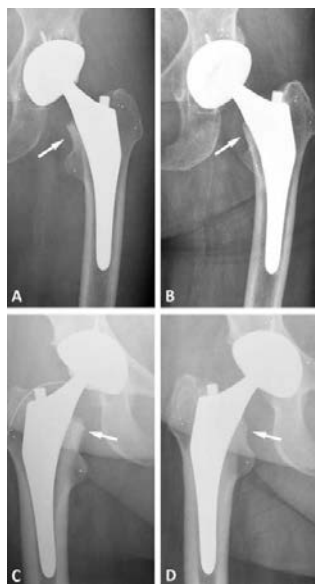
Adaptive remodeling. Radiographs taken postoperatively (A, C) and after 2-years (B, D) demonstrating bone changes in Gruen zone 7 in two of the THA patients. Bone loss is seen as rounding off of the medial periprosthetic bone (arrows) due to adaptive remodeling.
